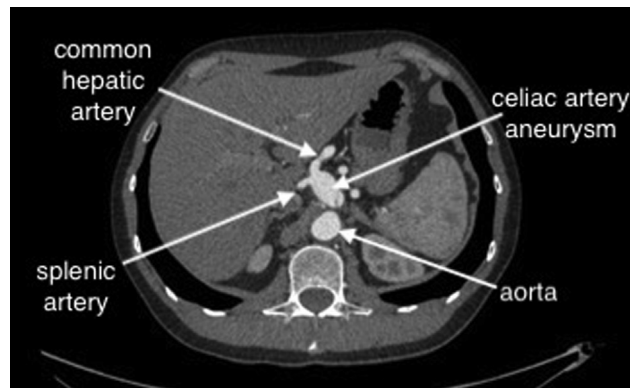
Preoperative computed tomography angiogram.
